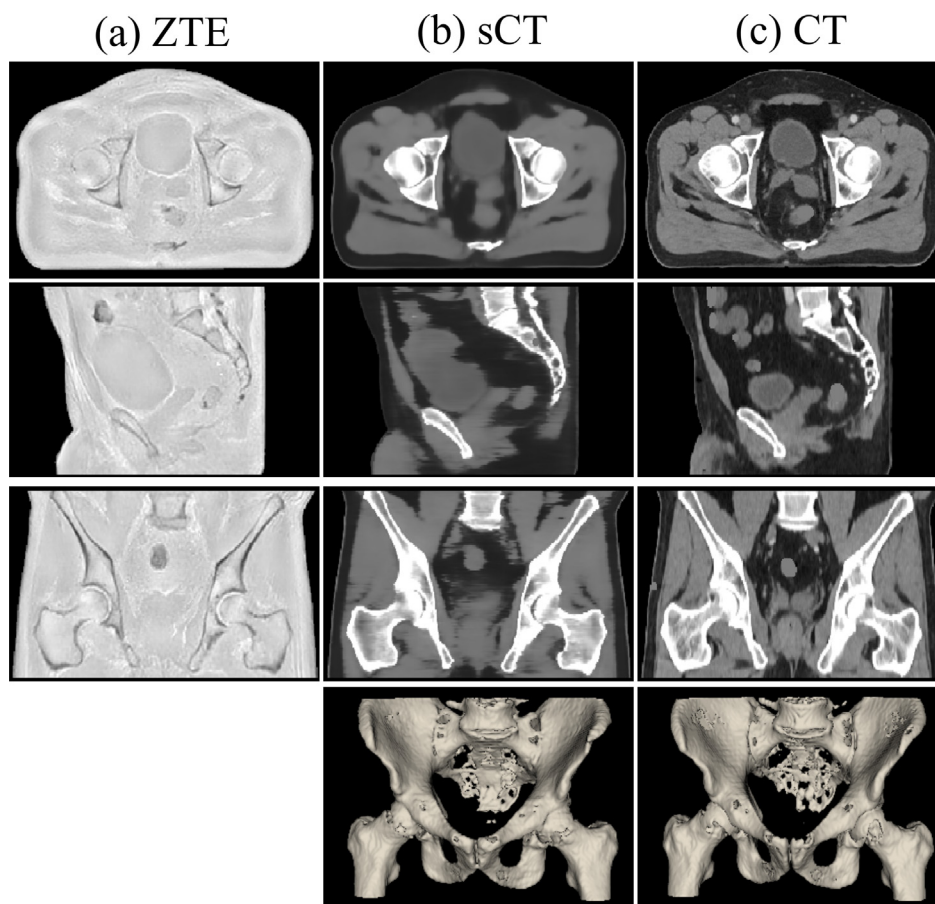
Example ZTE images (a) and corresponding sCT images (b) for a patient in the evaluation cohort. CT images for the same patient are shown in (c).
